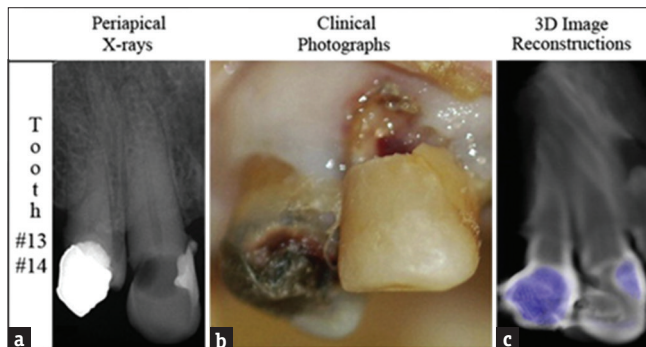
(a) dental restorative materials on peri apical X-ray, (b) dental restorative materials on clinical photographs (c) dental restorative materials on 3D image reconstructions
